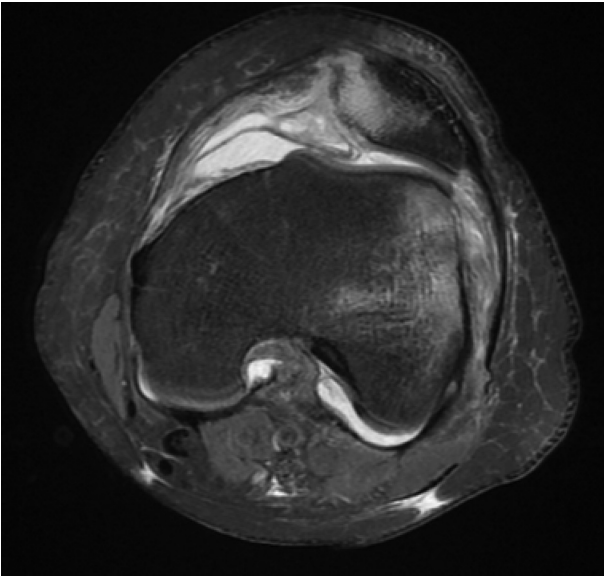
Axial MRI scan showing characteristic 'bone bruising' to the medial aspect of the patella and the lateral femoral condyle seen in a patella dislocation. In this case the trochlea is flat and dysplastic and is a significant risk factor for patella dislocation. They also have an effusion and have injured their medial patellofemoral ligament.
